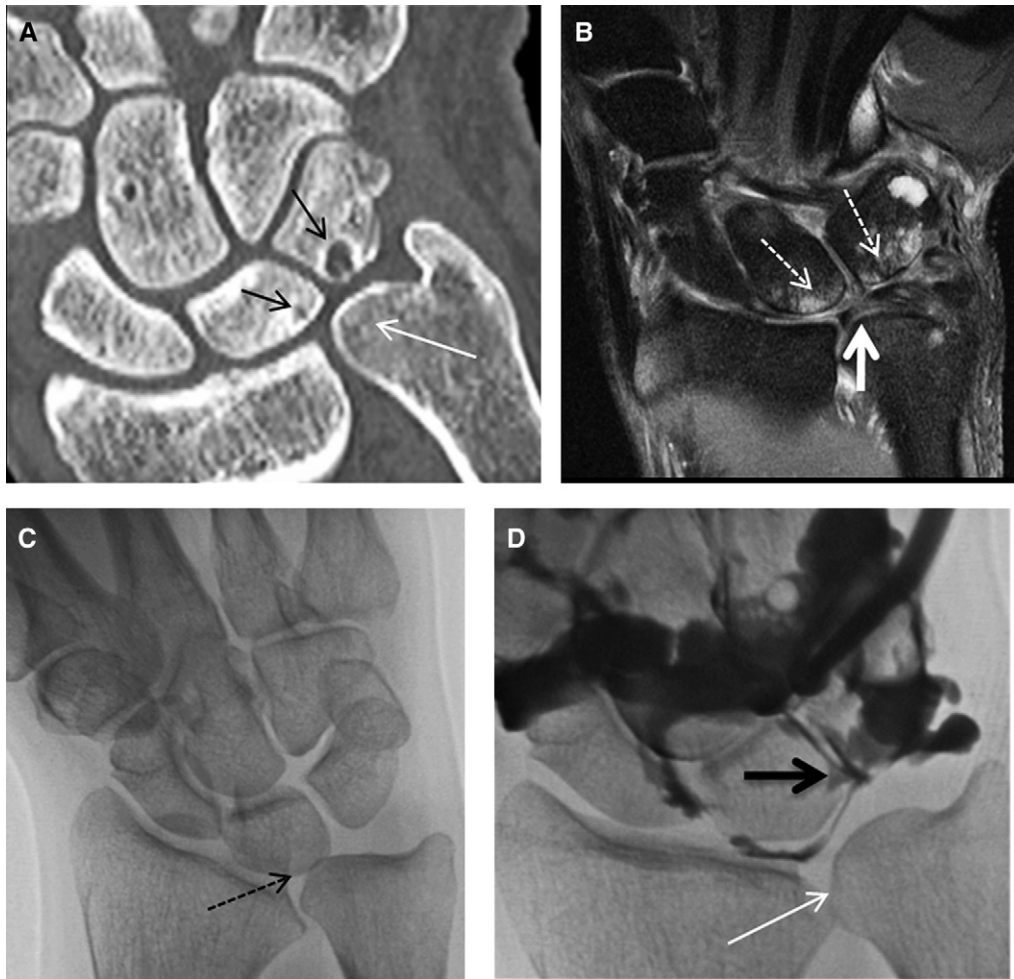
Ulnocarpal impaction. Computed tomographic coronal multi-planar reformat (MPR) (A), coronal proton density fat-saturated magnetic resonance image (B), prone anteroposterior radiograph with clenched fist (C), and fluoroscopic arthrographic image (D), demonstrating ulnar positive variance (thin white arrows), marrow oedema in the lunate and the triquetrum (dotted white arrows), subchondral cyst formation (thin black arrows), a lunotriquetral ligament defect (thick black arrow), and a central triangular fibrocartilage proper defect (thick white arrow). Notice the ulna abutting the lunate in the clenched fist position (dotted black arrow). Images (C) and (D) are of the same patient. Images (A) and (B) are of different patients.
